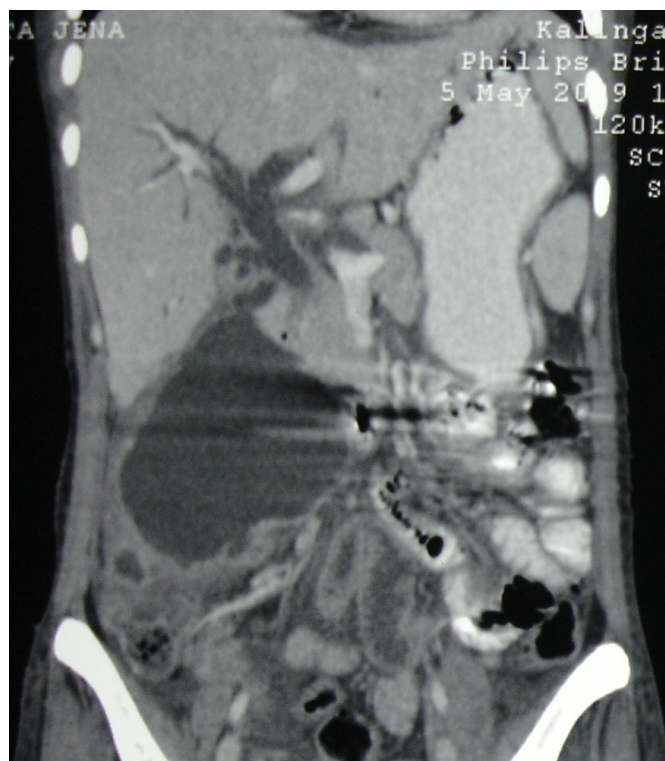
Coronal reconstruction of contrast enhanced CT scan showing collection extending from the bile duct to right paracolic gutter.
